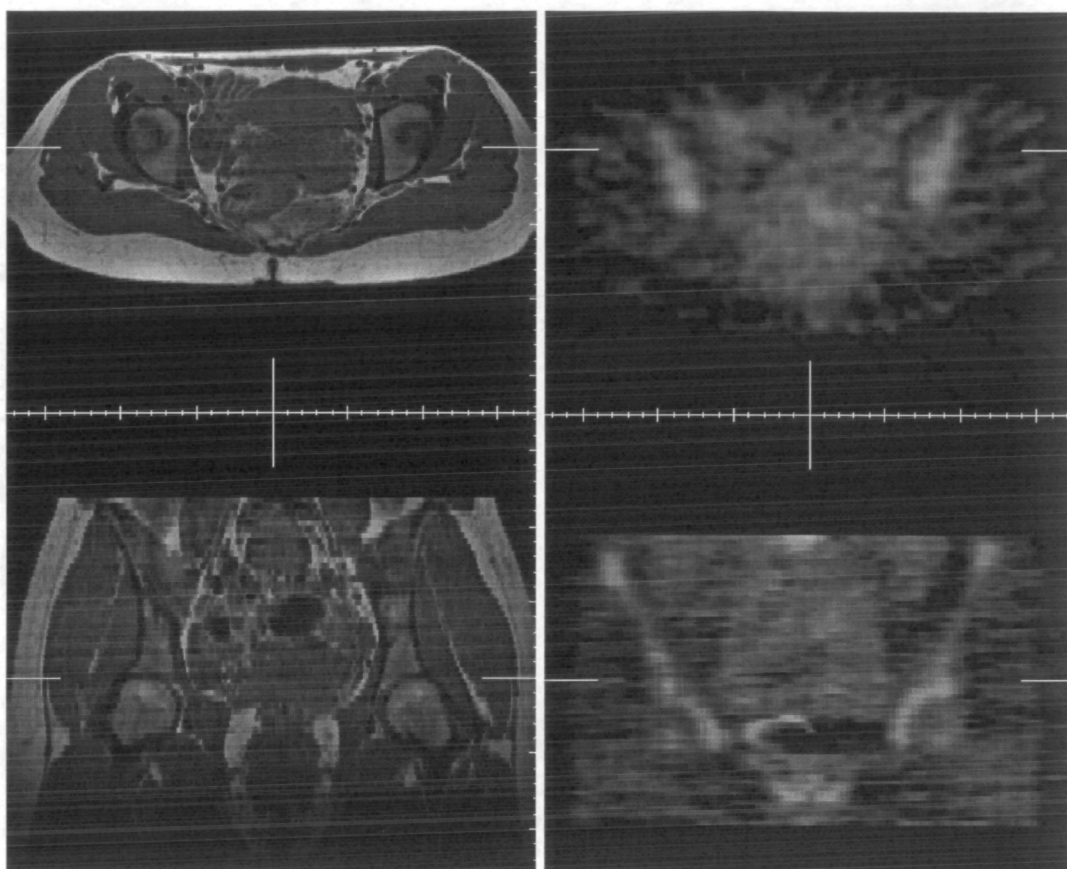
Orthogonal slices through a clinically acquired MR image volume (left) and corresponding PET image volume (right), manually registered.
